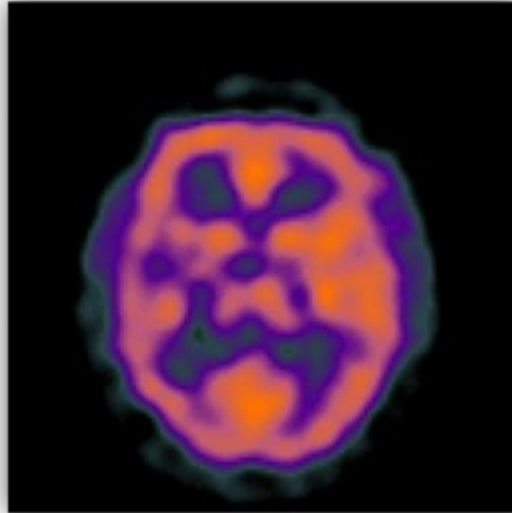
Typical SPECT image [5]
